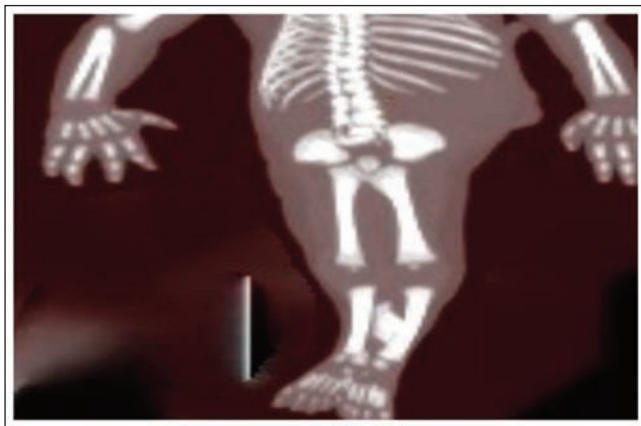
X-ray of patient admitted to the hospital with mermaid syndrome.
